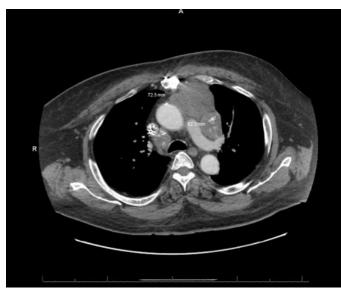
CT chest with IV contrast, 2018.
